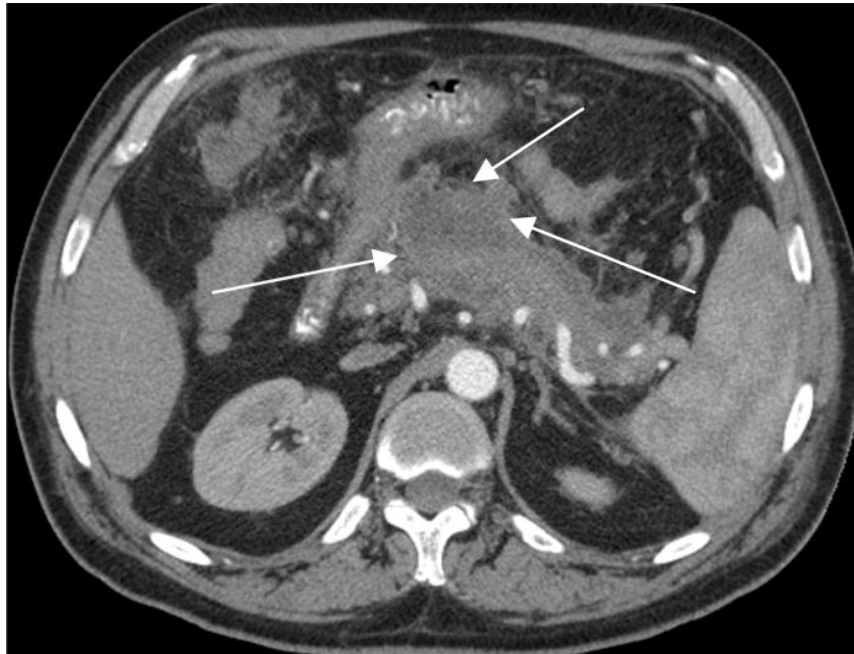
Patient Ch., 50 years, 3 days from the beginning of abdominal pain. AP of alcoholic etiology. The arrows indicate areas of reduced contrast in the parenchyma of the pancreas. With this picture interstitial edematous pancreatitis and necrotizing pancreatitis can't be unambiguously differentiated, which will become possible in subsequent CT studies.
